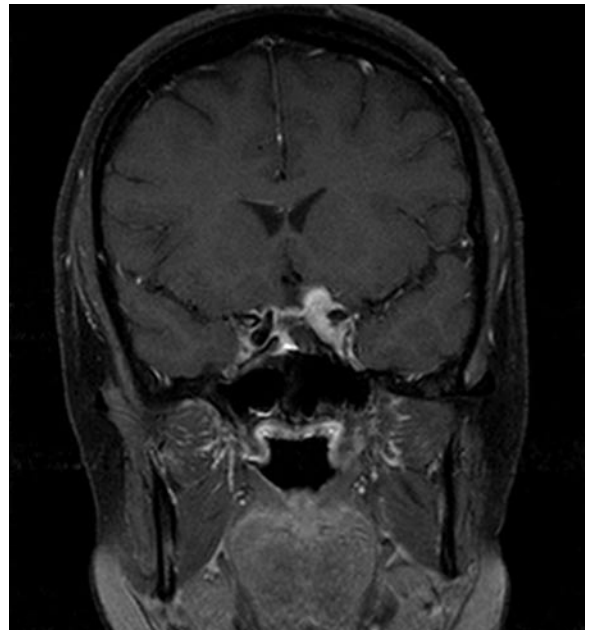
Lymphocytic hypophysitis. Coronal T1-weighted image with suppression of the signal of fat (fat saturation) after contrast administration. Widened cavernous sinus on the left side. The granulomatous tissue does not respect the border of the cavernous sinus and spreads above to compress the entorhinal cortex. Note that there is absent flow void in the distal left carotid artery
